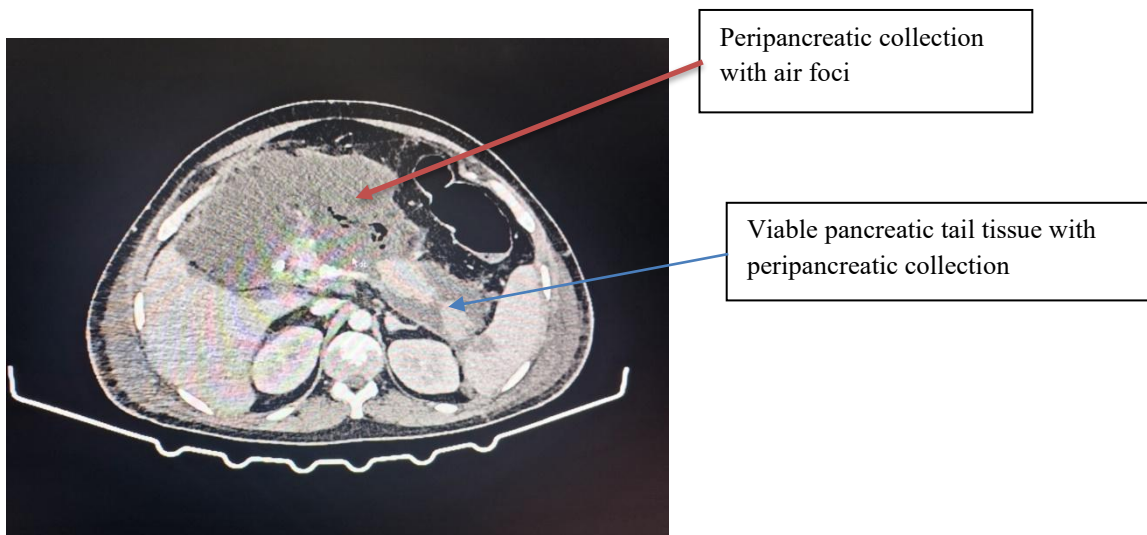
CT Abdomen showing necrotic pancreas and peripancreatic collection
